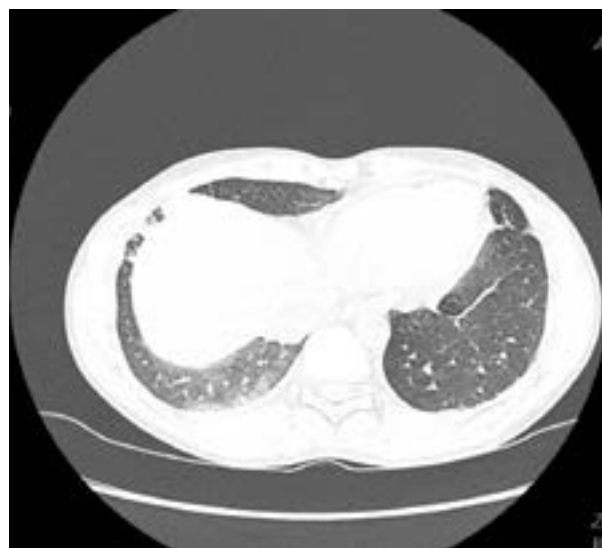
Computed tomography scan demonstrating right lower lobe consolidation
